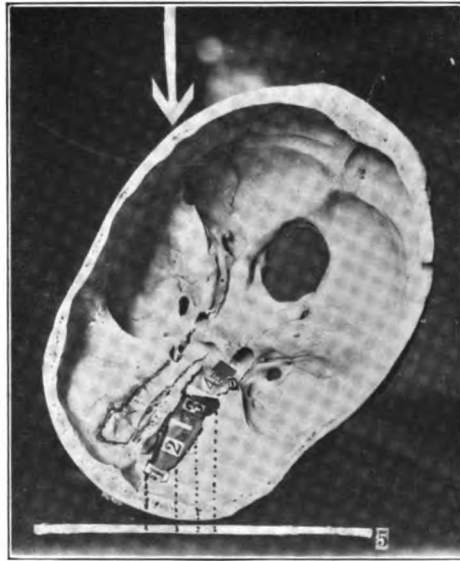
Position of skull, and direction of central rays, marked by arrow; 5, Roentgen-ray plate; 1, roof of frontal sinus; 2, of anterior ethmoids; 3, of posterior ethmoids; 4, of sphenoid. Dotted lines indicate projection onto plate.
